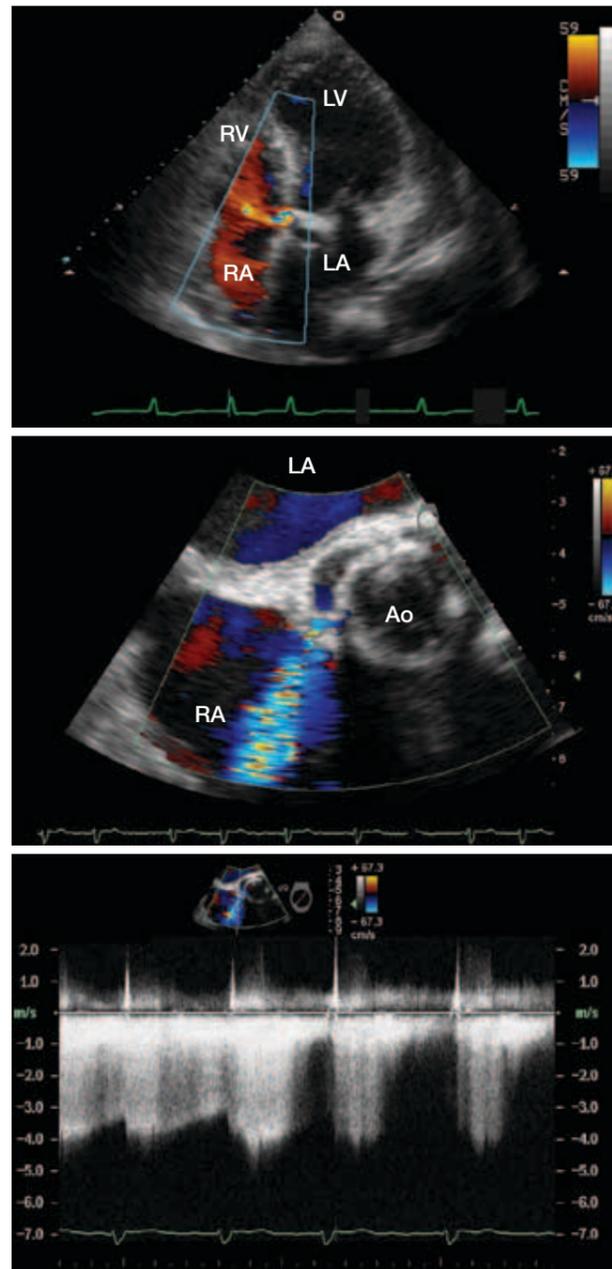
A fistulous communication between the aorta and the right atrium (RA) is suspected from the apical 4-chamber image where abnormal flow from the aorta to the RA is seen (top). On the corresponding transoesophageal echocardiogram, an echolucent cavity was noted around the aortic root (Ao) with fistulous flow between this cavity and the RA noted on colour flow imaging (middle). Via continuous-wave Doppler, high velocity, continuous flow was also observed confirming a shunt from the higher pressure aorta to the lower pressure RA (bottom). LA = left atrium; LV = left ventricle; RV = right ventricle.
